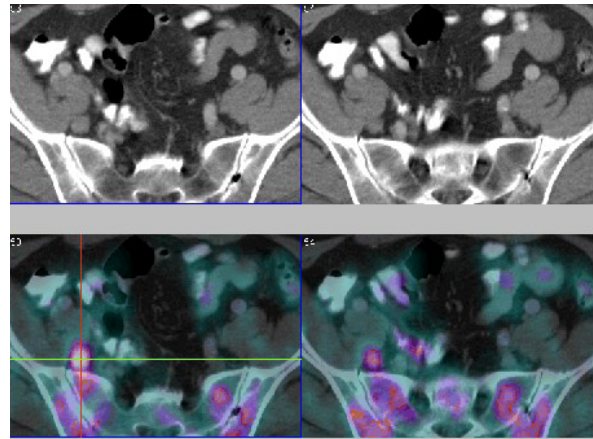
$[^{18}\text{F}]\text{FECh}$ PET/CT: detection of a previously unknown lymph node metastasis in the pelvis.
